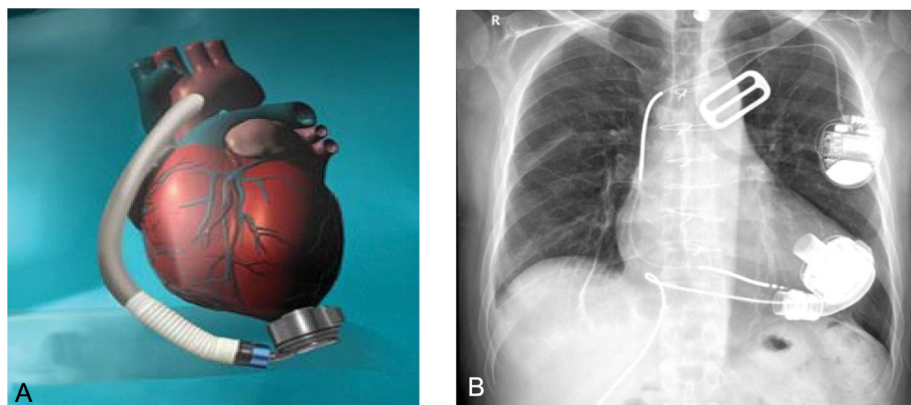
(A) HeartMate III continuous flow left ventricular assist device (LVAD) with the inflow cannula in the left ventricular apex and the outflow cannula in the ascending aorta. (B) Chest X-ray, posteroanterior view of our patient, showing the HeartMate III in place with the inflow and outflow cannulas and the driveline. The cardiac resynchronization therapy-defibrillator (CRT-D) device and the leads are shown.
